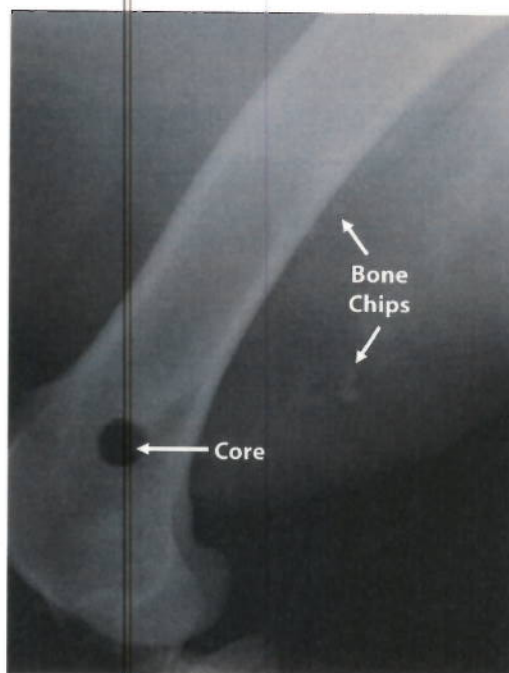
Radiograph obtained after 5 AID blasts revealed that the bone chips placed on the lateral side of the femur had migrated posteriorly as well as into the adjacent muscle tissue.
